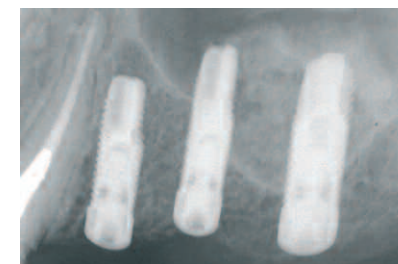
Radiographically, Bio-Oss® particles are observed during the follow-up.
